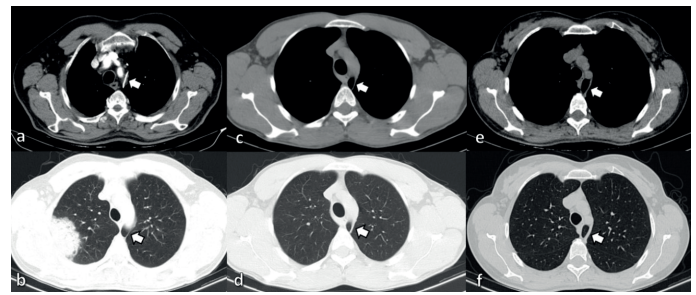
(a) You can see normal posterior superior intercostal vein course (white arrow) on axial enhanced thorax CT image. The other images (b-f) there are case examples of left upper lobe entrapped medially by an aberrant course of posterior superior intercostal vein, «left azygos lobe» can be seen (white arrows).
